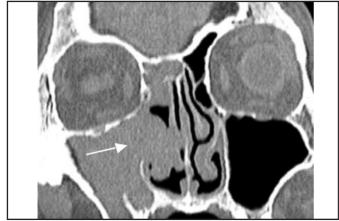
Coronal CT of patient with polyp. Note the expansile lesion in the nasal cavity extending from the right maxillary sinus. There is widening of the right maxillary ostium (arrow).
